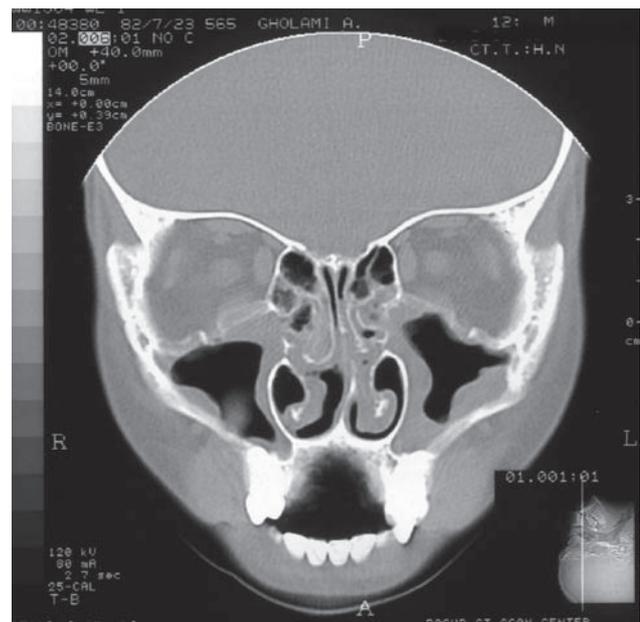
Sinus computed tomography, in computed tomogram of para nasal sinuses multiple polyps and hypertrophic mucosa were seen.
